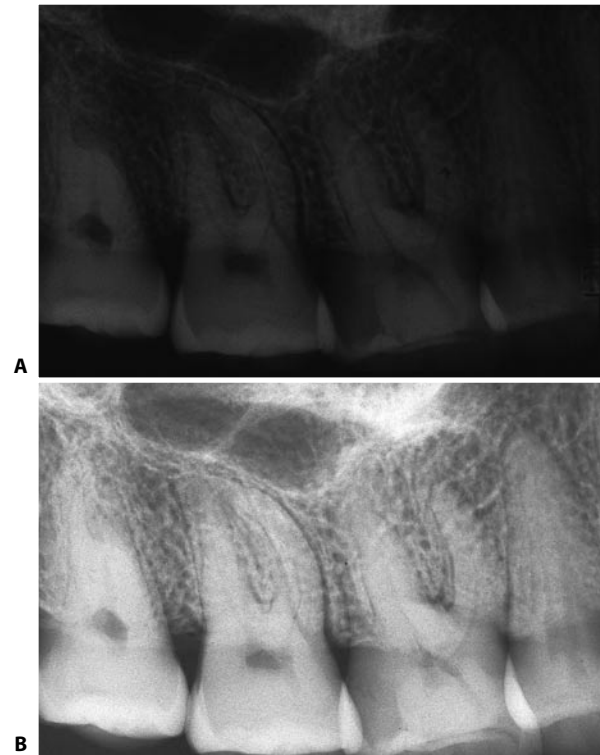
A. Radiograph performed with a long exposure time: it is dark because of overexposure. B. Radiograph of the same area, performed with the proper exposure time.
